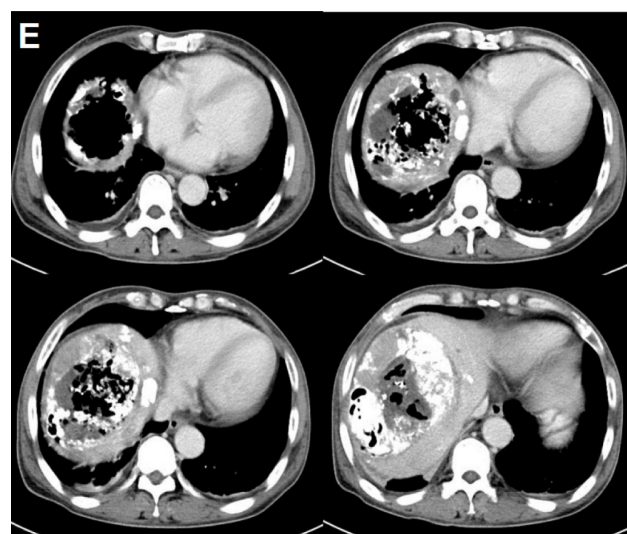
(E) CT examination after treatment revealed extensive necrosis and cavitation in the liver of patient B.
